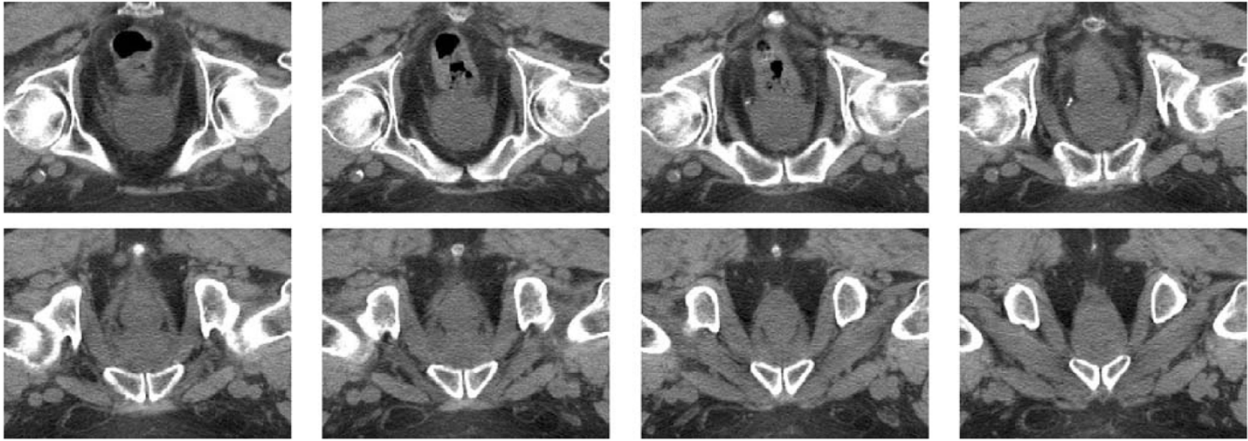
Evenly spaced axial slices of scan 6082, without segmentation. Eight sequential slices of the CT volume are displayed (out of the 35 total slices input to the algorithm).
